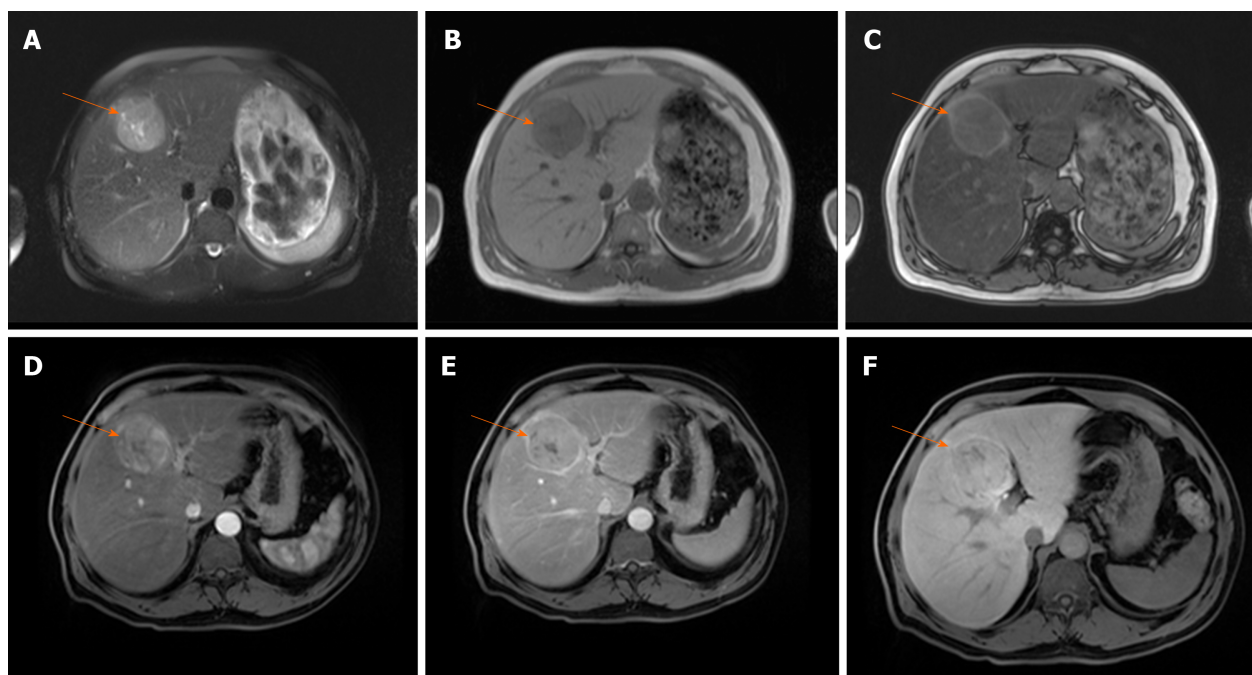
Hepatocellular carcinoma in 54-year old man with non-alcoholic fatty liver disease. A: Axial T2-weighted FS image shows hyperintense lesion (arrow) in segment IIVb; B and C: Dual-echo images show that tumor (arrow) is hypointense on in-phase image (B) without signal drop on opposed-phase image, while background liver parenchyma shows diffuse signal drop as a consequence of fatty liver disease (C); D and E: The lesion (arrow) is hypervascular on arterial phase (D) without washout on portal-venous phase (E); F: On hepatobiliary phase the nodule (arrow) is isointense with surrounding liver parenchyma.
